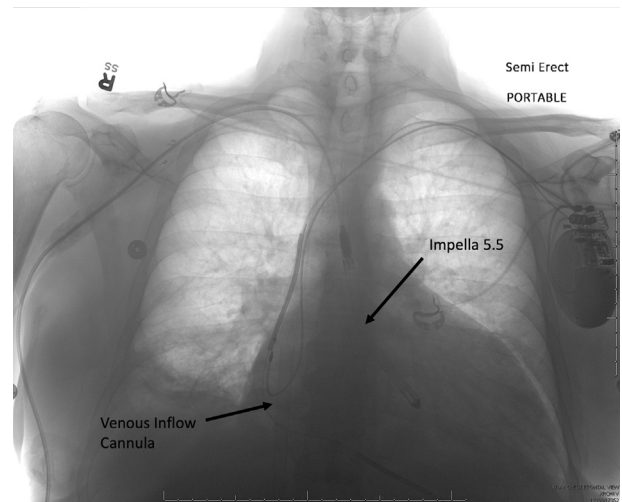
Chest roentgenogram following cannulation for peripheral venoarterial extracorporeal membrane oxygenation and axillary Impella 5.5.
